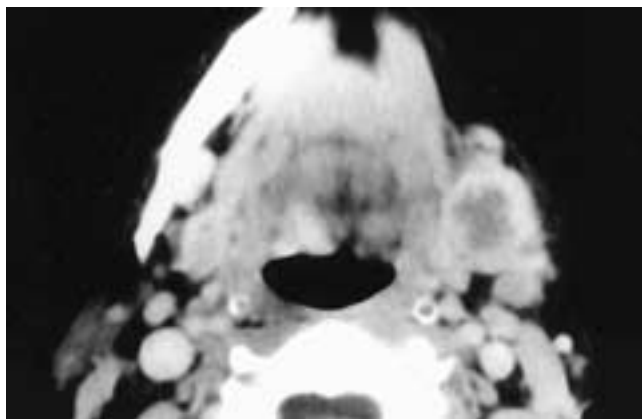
Axial CT scan shows a necrotic mass in the left submandibular gland. The tumor has a thick, irregular rim and an infiltrative outer contour. This patient had a high-grade MEC.
